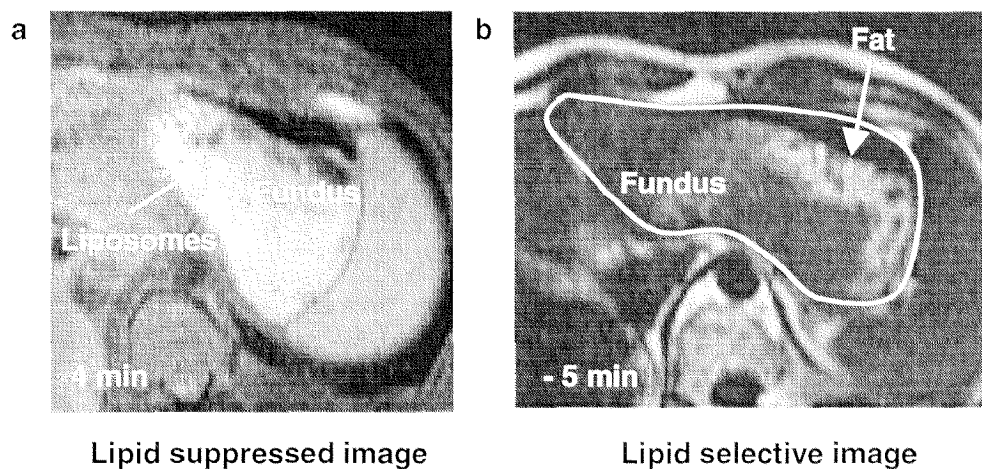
MR image showing the distribution of the colloidal drug model (a) and dietary fat (b, before capsule intake) in the fundus after ingestion of the solid meal.
